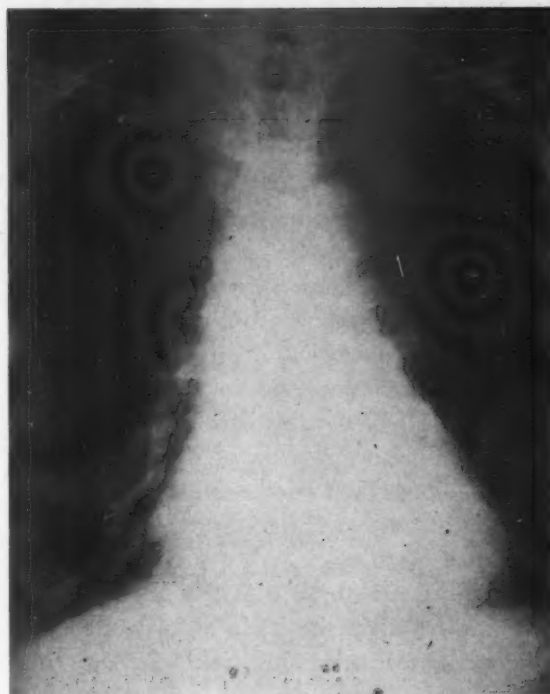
X-ray film of chest taken on May 7, 1956, revealing complete disappearance of the previous pulmonary metastases seen in Figs. 3 to 5.
